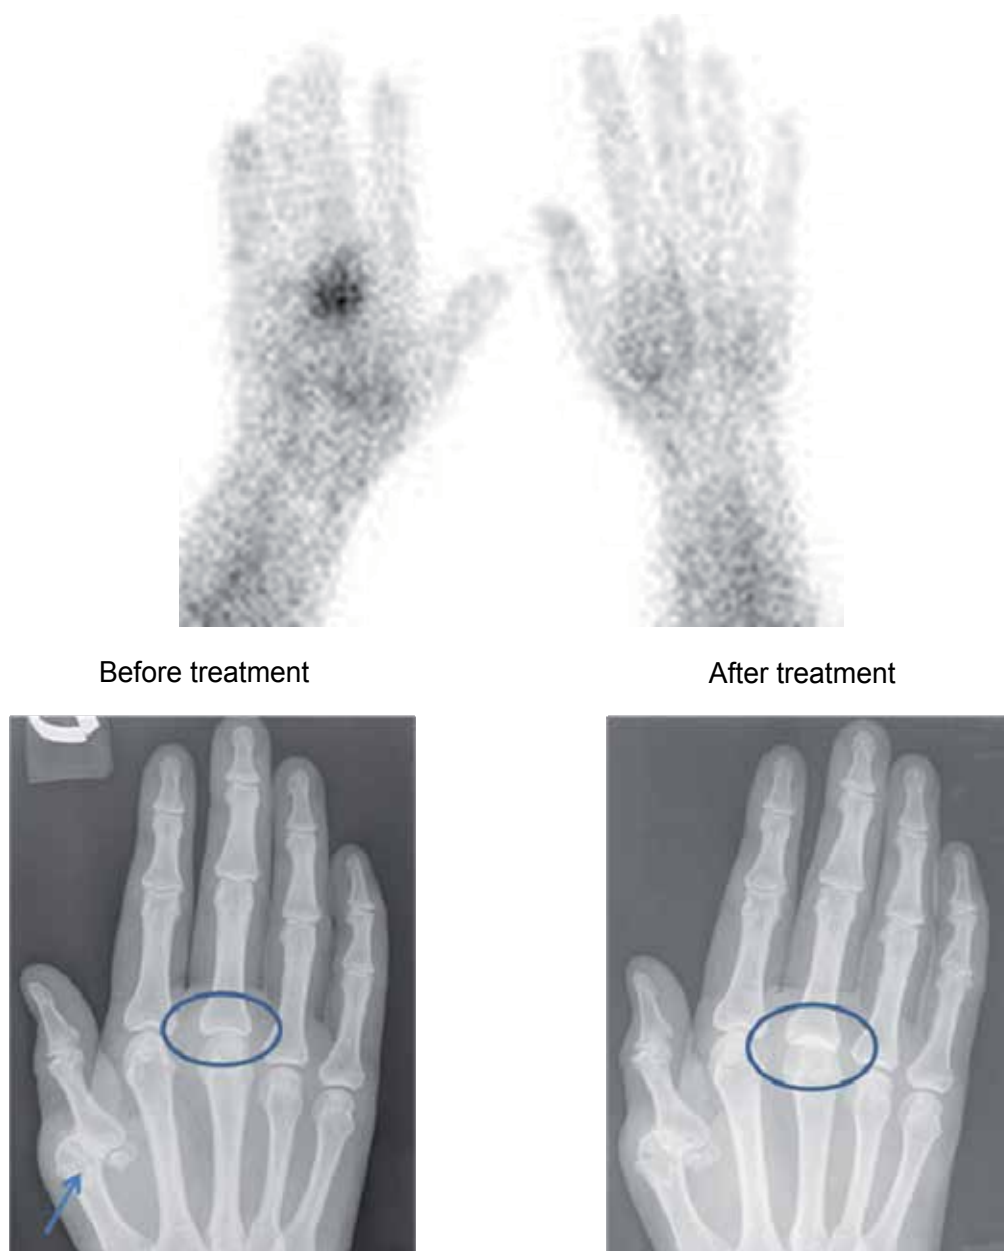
Patient with a known CNO secondary to syringomyelia involving 1<sup>st</sup> right MCP (arrow). She developed a 3<sup>rd</sup> MCP swelling joint, early detected with scintigraphy. Initial radiography did not show any changes. Treatment was administered very early avoiding established deformities.
